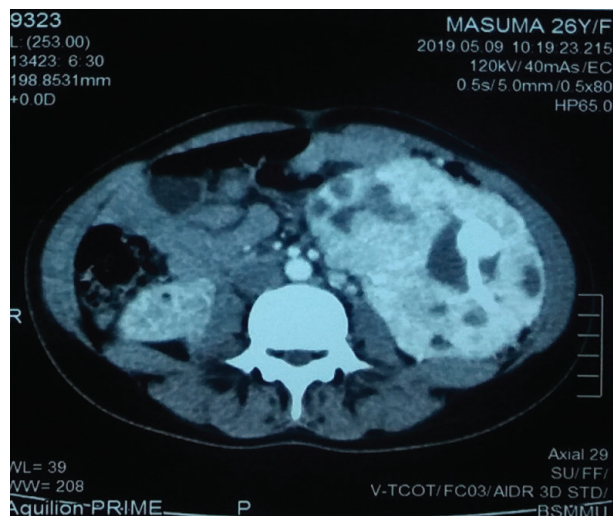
CT scan of abdomen revealed bilateral angiomyolipomas, right measured 4.2×3.9×3.1 cm while left measured 16.4×11.3×6.8 cm
